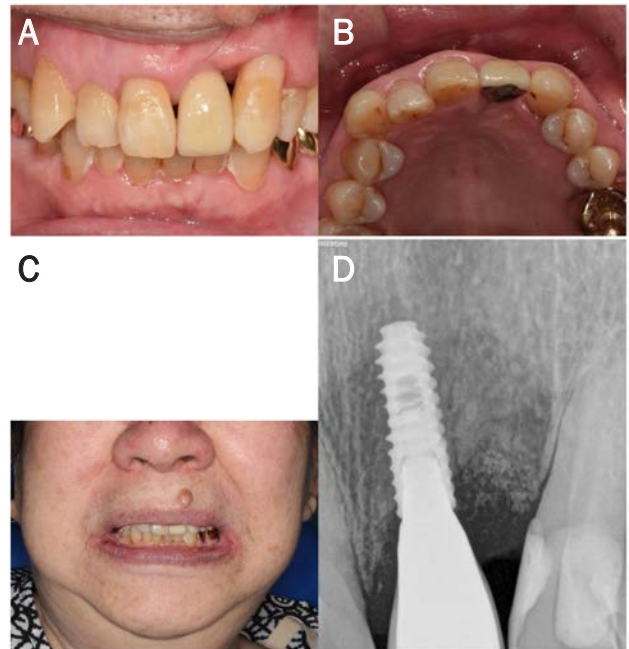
Post-operative photographs. (A) Frontal view. (B) Occlusal view of maxilla. (C) Smile view. (D) Periapical radiograph.
